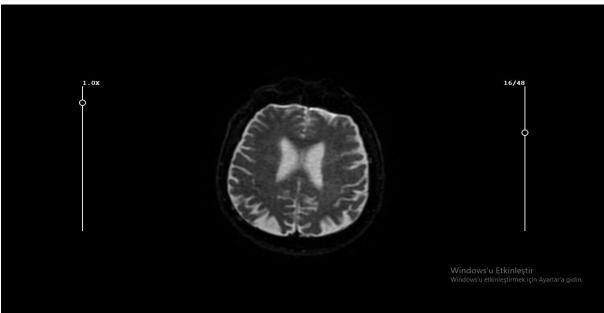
Indiffusion Brain MRI Apparent Diffusion Coefficient (ADC), no evidence of acute diffusion restriction.
